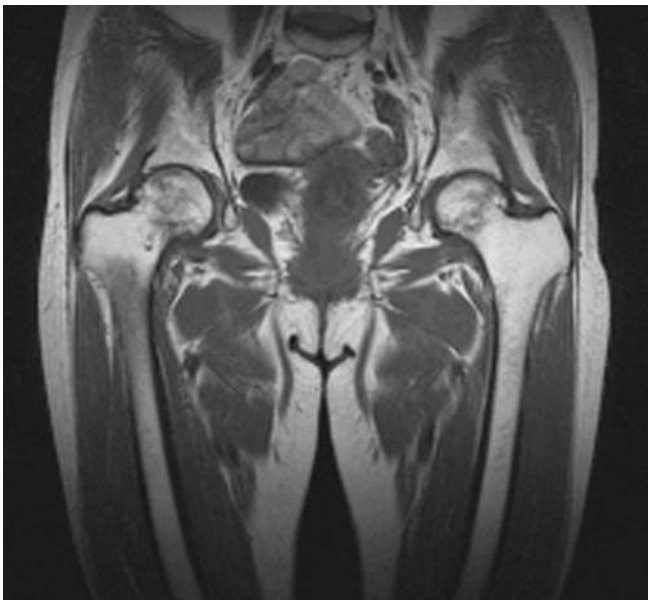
T1-weighted magnetic resonance imaging showing a low-signal-intensity area centered around the subcapital zone in a band on the left hip, and porphyricity in the whole head to neck area in the right hip
